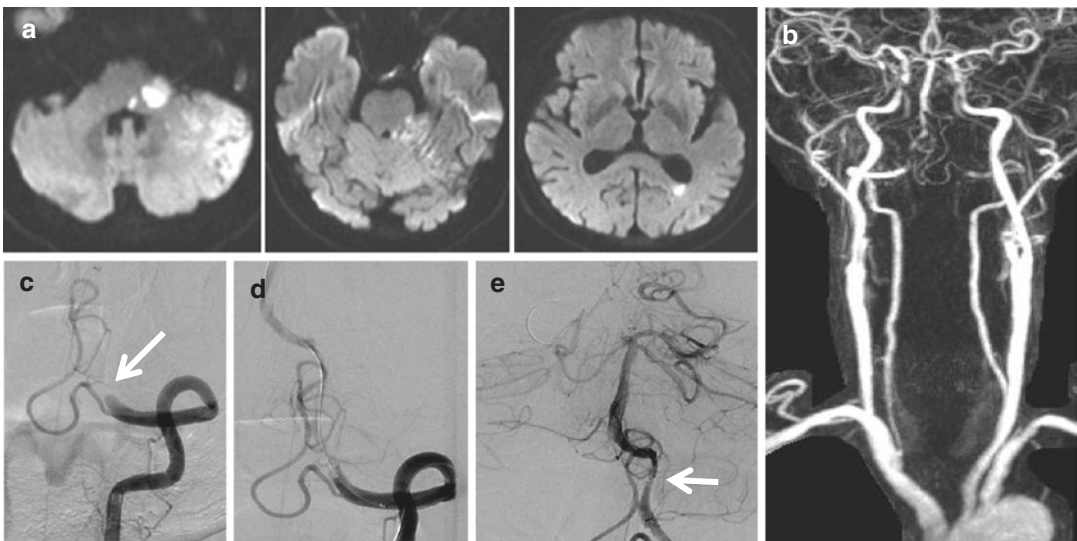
A 65-year-old man with a history of hypertension and diabetes mellitus developed recurrent episodes of dizziness for a few days, followed by sudden vertigo, dysarthria, and gait ataxia. Diffusion-weighted MRI showed acute infarcts in the right pons, cerebellar peduncle, cerebellum, and occipital area (a). MR angiogram showed bilateral steno-occlusion in the distal vertebral arteries (VAs) (b). Initially, he was alert, but he became drowsy
